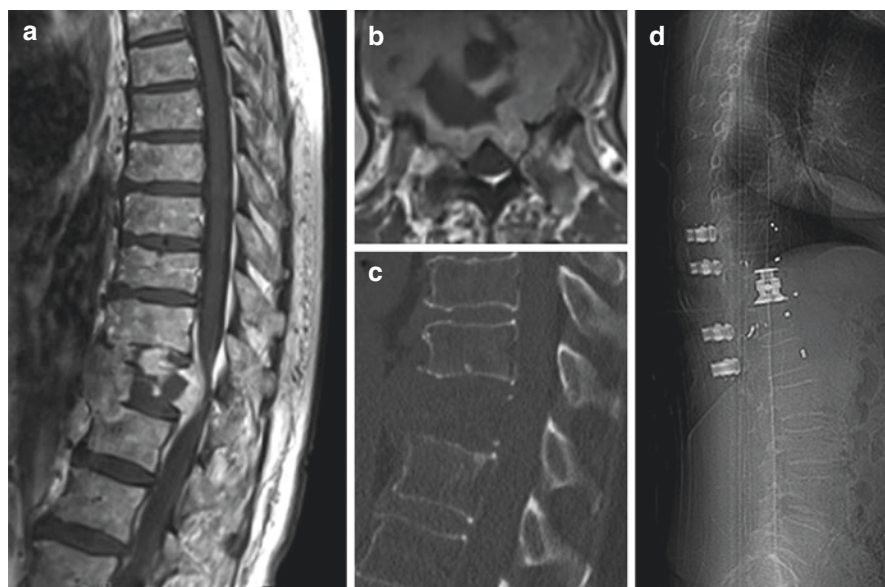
Example of a 67-year-old female suffering from metastatic renal cell carcinoma with osteolytic spinal metastasis at Th11, clinically presenting with pain and ataxia. Following angiographic embolization of the metastasis, 360° decompression and stabilization were performed via vertebral body replacement Th11 with cage implantation and posterior stabilization with navigated pedicle screw placement Th9–L1 using PEEK carbon pedicle screws for better MRI follow-up and adjuvant radiation planning. Preoperative images a–c, postoperative image d
